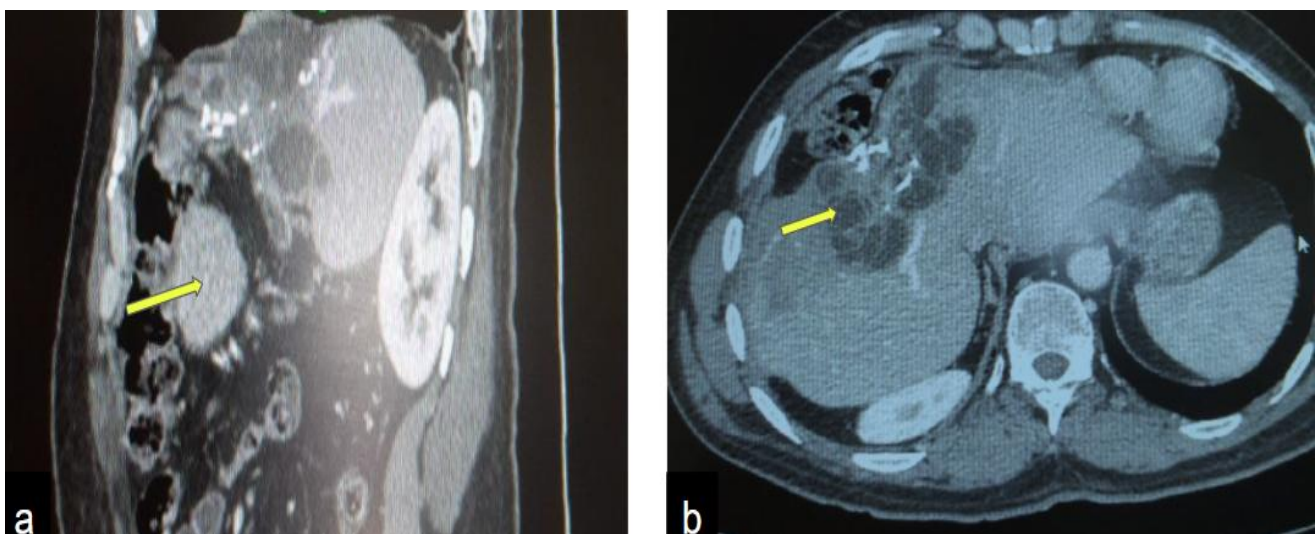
(a) Abdominal CT scan image showing a subhepatic peritoneal hydatid cyst (yellow arrow) and (b) abdominal CT scan photo showing an associated hepatic cyst suggestive of hydatid origin (yellow arrow).
